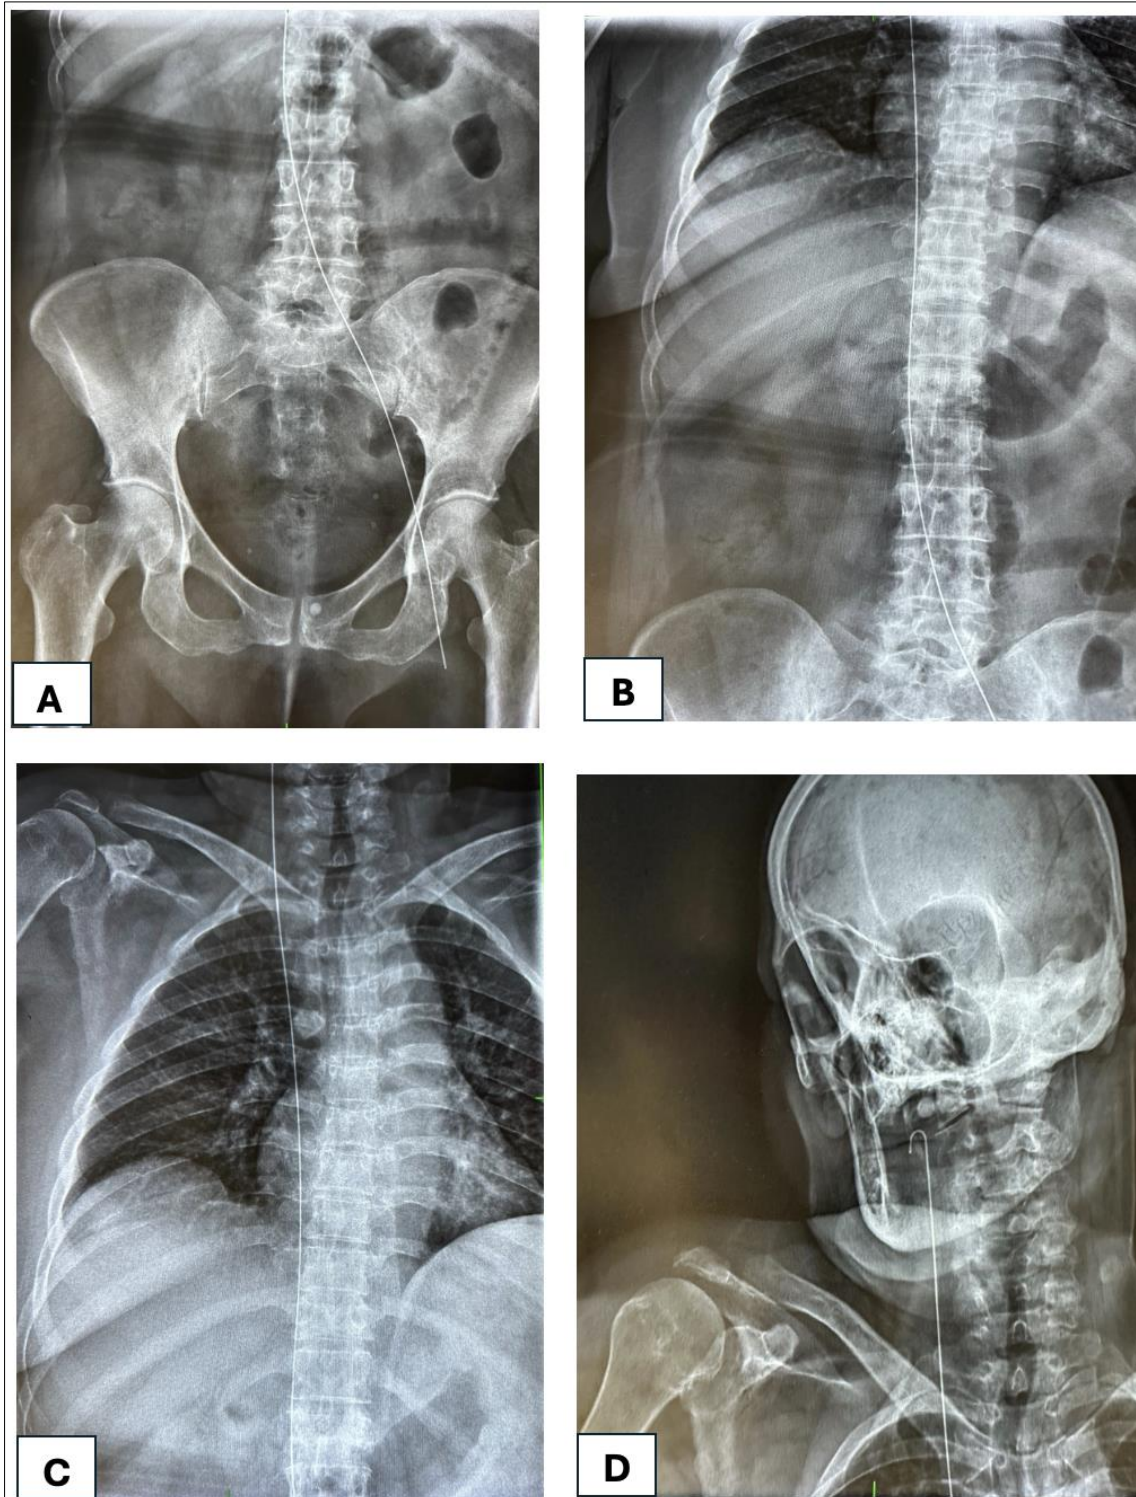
X-ray images: right femoral catheter’s guidewire migration along the natural venous anatomical pathway (femoral vein, inferior vena cava, superior vena cava, internal jugular vein) without deviation or entrapment
